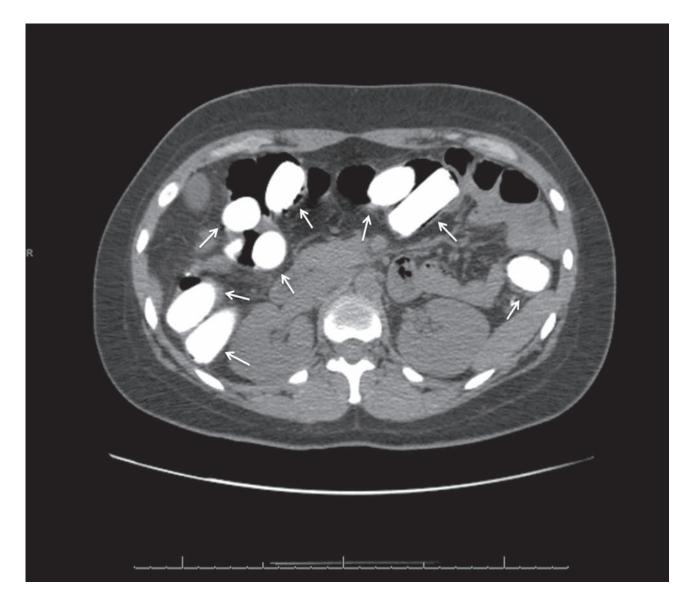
Admission CT Abdomen/Pelvis
